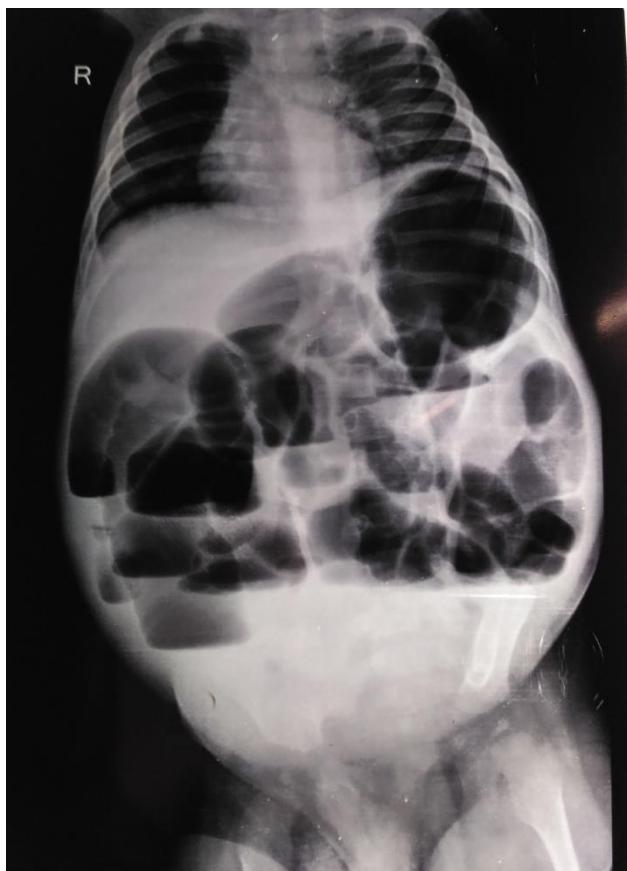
Plain erect abdominal radiograph of the patient showing multiple air-fluid levels.
